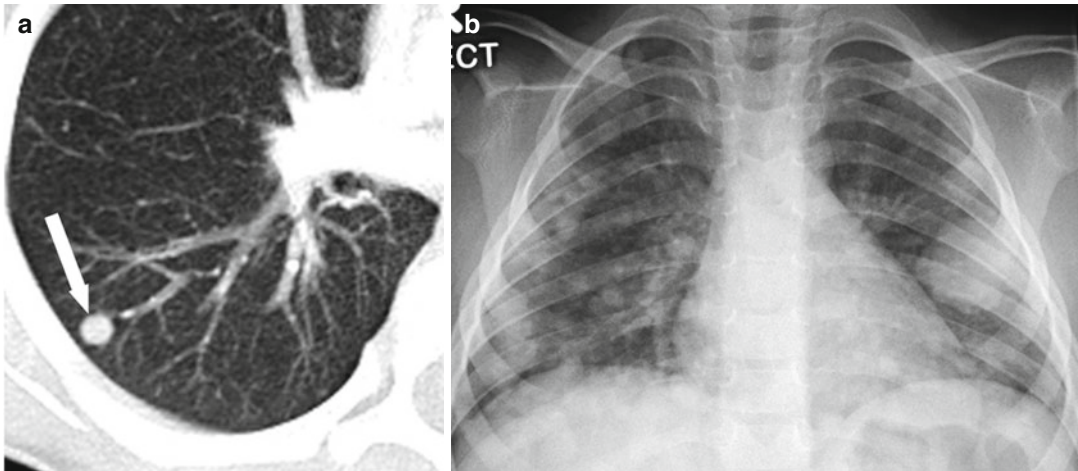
Large (cannonball) lung metastases seen on chest radiograph (a), small metastasis seen on CT (b). A round, well-demarcated lesion raises the suspicion of metastatic lung disease even with a small number of low-volume lesions
